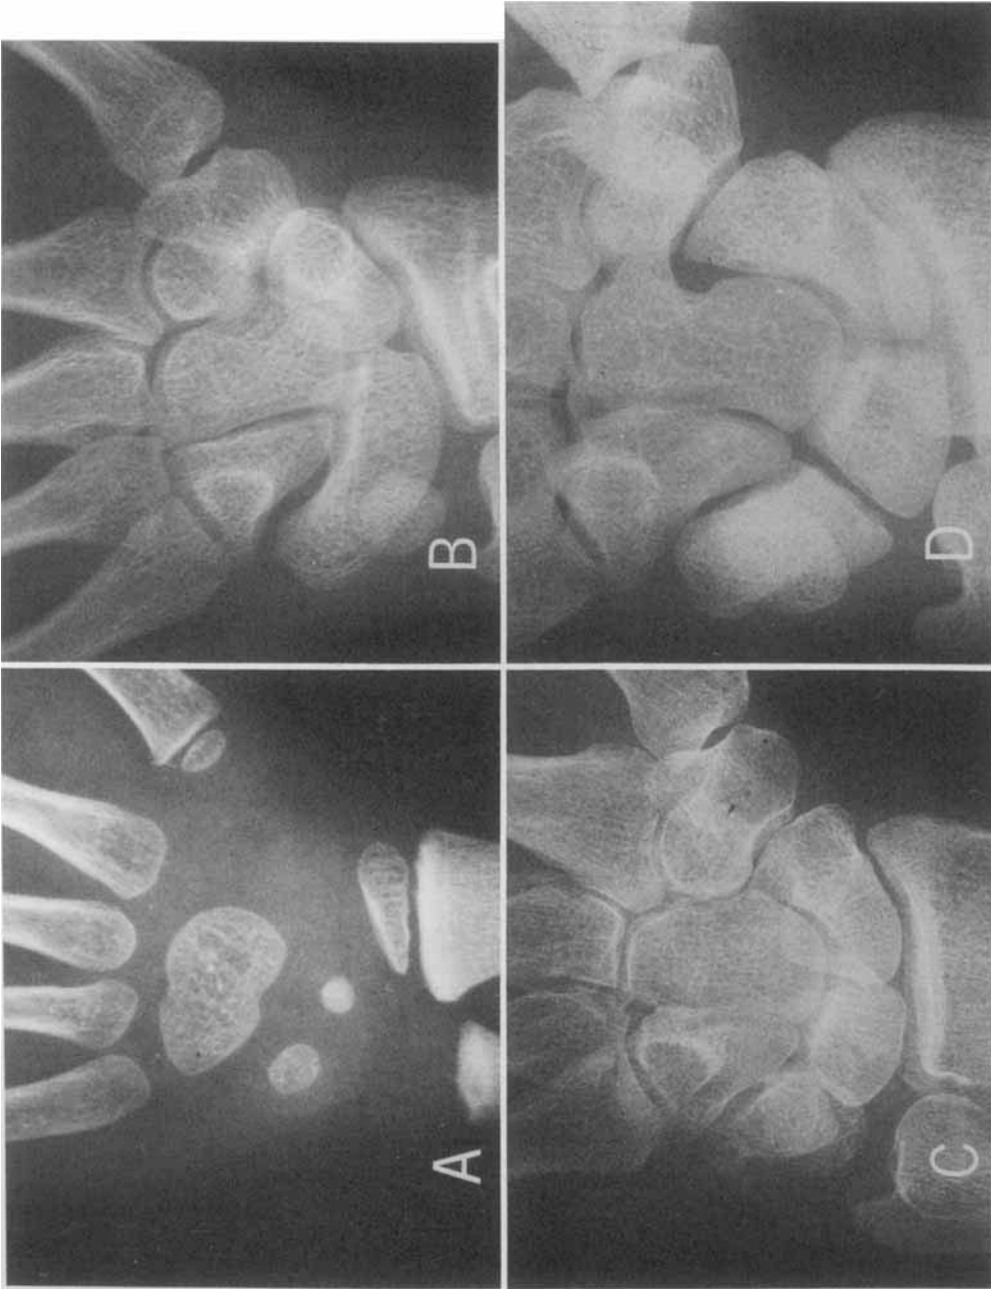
Postero-anterior radiographs of children and adults showing a Capitrate-Hamate fusion (A), a Lunate-Triquetral fusion (B), a Trapezium-Trapezoid fusion (C) and a Capitrate-Trapezoid fusion at (D). Many fusions are difficult to verify from the postero-anterior hand projection alone, but these four examples are selected from approximately 200 clear-cut fusions observed in the study of 21,715 radiographs of suitable quality.
